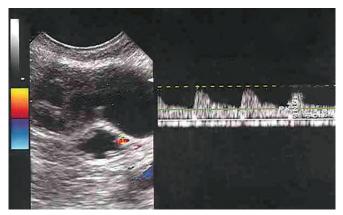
Sign of color Doppler throughout the tube suggesting acute infection
